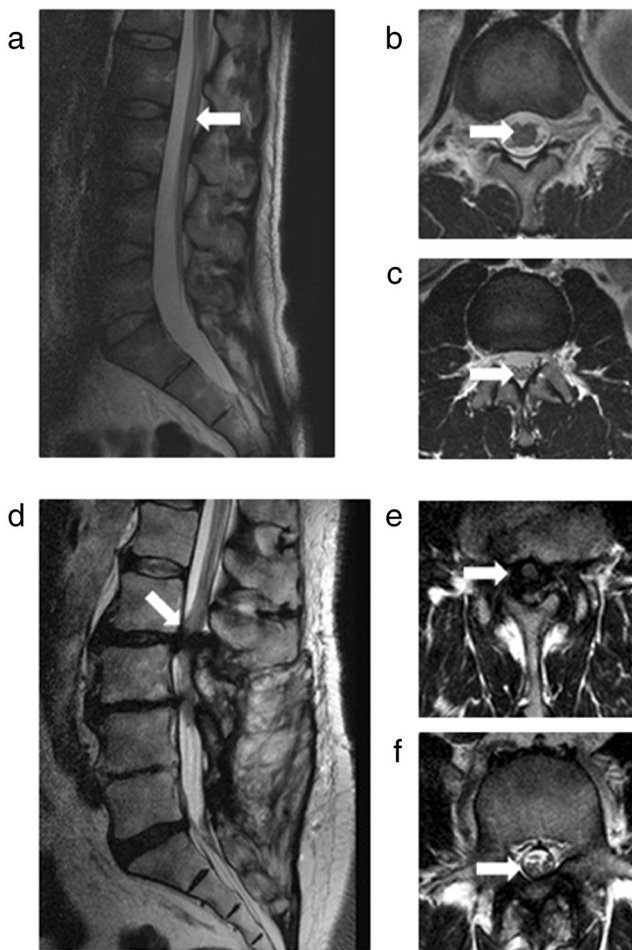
Magnetic resonance imaging of the lumbar spine. *Top panel (a, b, c):* normal lumbar spine MRI; a sagittal T2-weighted image demonstrating lower spinal cord, lumbosacral roots (*arrow*), and surrounding bright cerebrospinal fluid (CSF), b axial T2-weighted image demonstrating lower spinal cord (*arrow*) surrounded by CSF, and c axial T2-weighted image showing lumbar sacral nerve roots (cauda equina, *arrow*) surrounded by CSF. *Bottom panel (b, e, f):* lumbar spine MRI findings in severe lumbar spinal stenosis; d sagittal T2-weighted image showing compression of the lower spinal cord and roots (*arrow*) with no surrounding CSF, e axial T2-weighted image showing lower spinal cord compression with no surrounding CSF visible (*arrow*), and f lower down the lumbar sacral nerve roots are visible within CSF below the area of severe stenosis (*arrow*)
